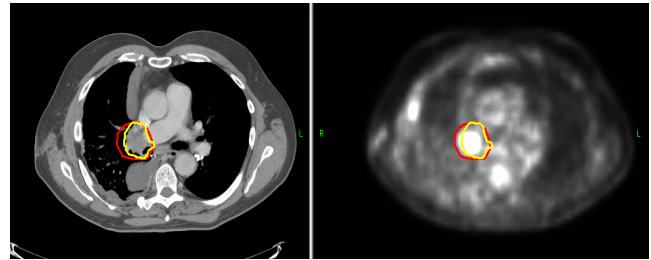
CT-GTV and PET-GTV shown on a representative image slice. The red solid line represents the PET-GTV and the yellow solid line represents the CT-GTV. The image on the left is the treatment planning CT and the image on the right is PET.
